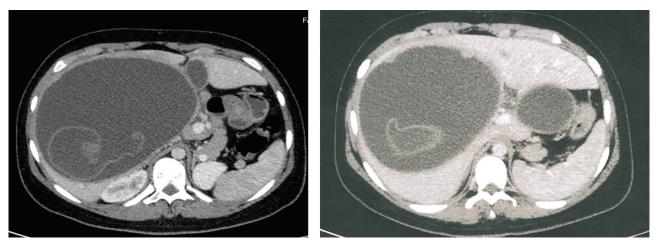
Abdominal CT scan revealed two cysts in the liver, one giant cyst measuring about $24 \times 20 \times 15$ cm in the RHL with pressure effect on the right kidney, pancreas, and bowel loops and another smaller one measuring $9 \times 8 \times 8$ cm in the LHL.
